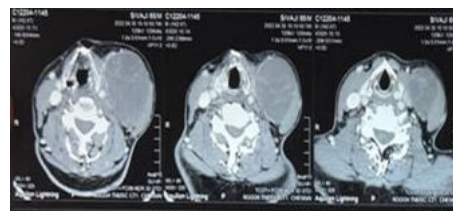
CT Neck showing left cervical cystic lesion
